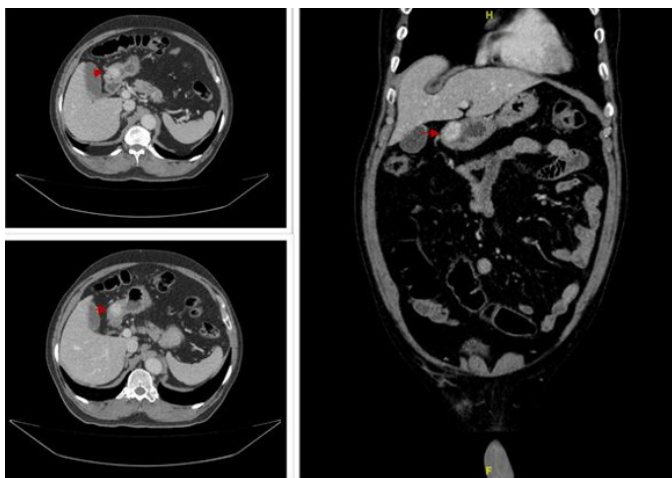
Contrast-enhanced CT scan—axial and coronal images showing a well-defined homogeneously enhancing lesion in the antro-pyloric region of the stomach.
